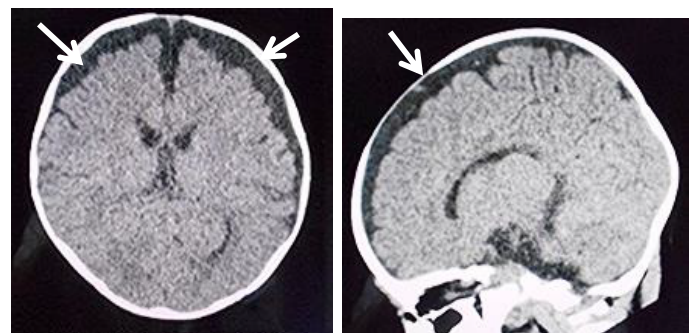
CT at the age of 3 months, presenting with a seizure
